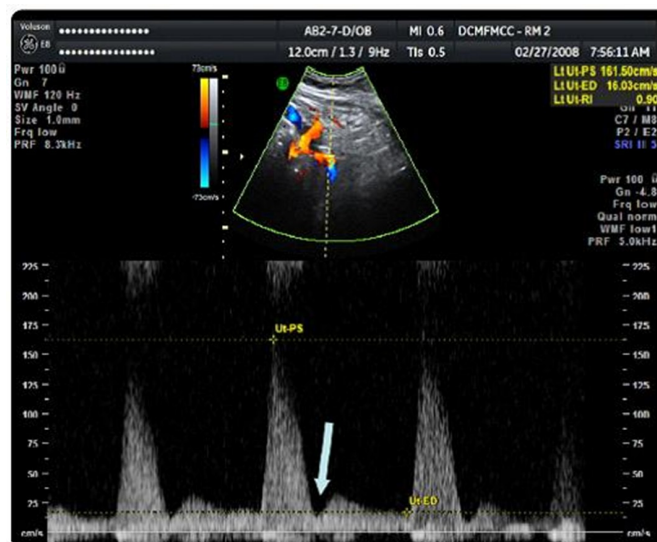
Uterine artery notching in doppler (Mariana et al , 2020) ¹²
